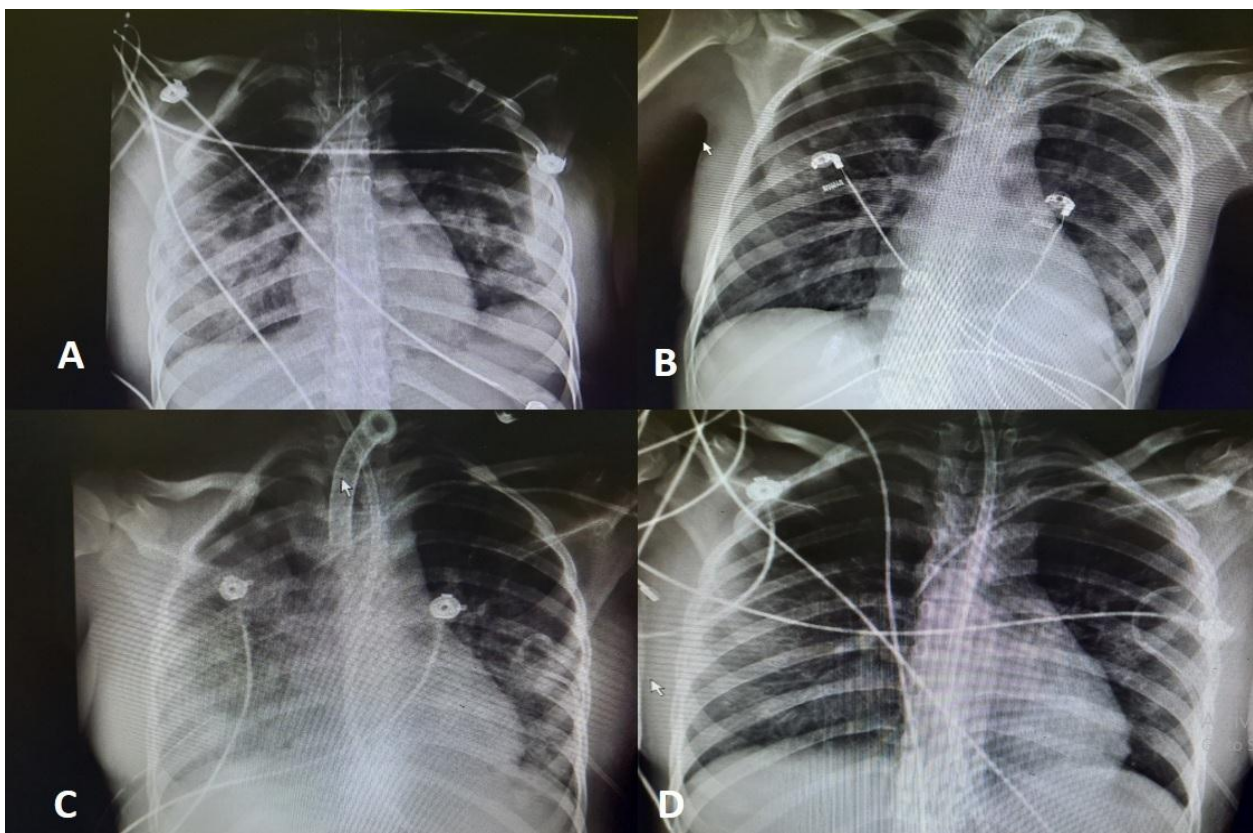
Chest Xray of patient. A: Day 1 at admission in hospital. B: Day 20 after recovery. C: Day 22: after suspicious Of COVID 19. D: Day 44 before discharge
